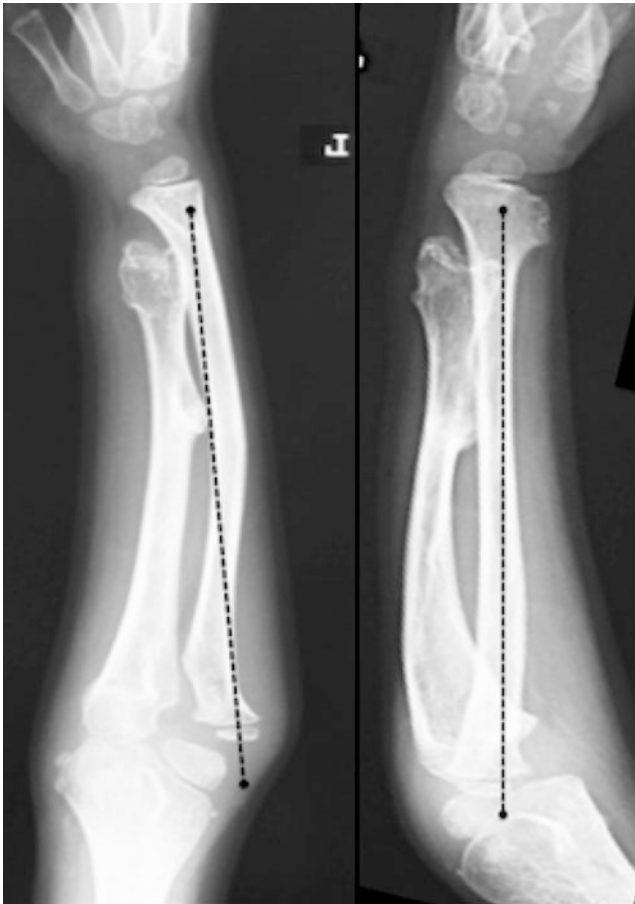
Radiograph of the left forearm at age 6 showing lateral subluxation of left radial head
